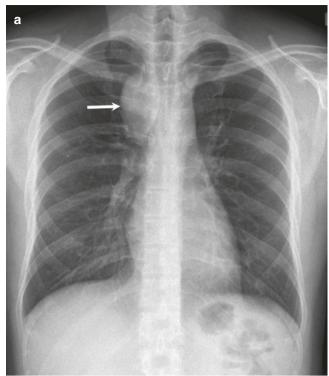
56-year-old man with right lower paratracheal stripe widening due to enlarged azygos vein from azygos continuation. (a) Frontal radiograph shows a mass in the tracheobronchial angle and right lower
